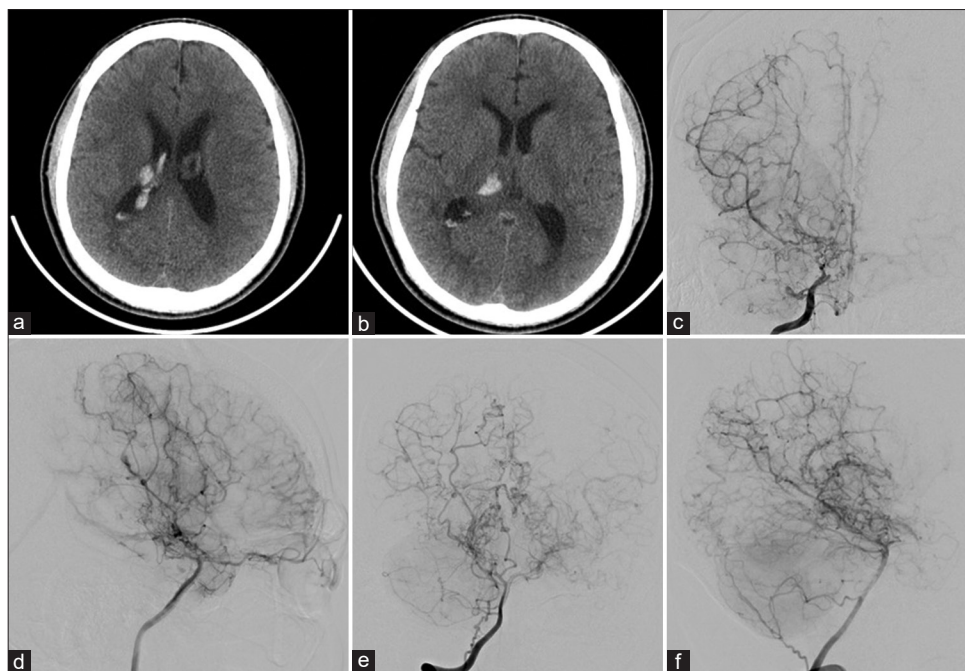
(a and b) Computed tomography revealing thalamic hemorrhage. (c) Anterior-posterior and (d) lateral angiography of the right internal carotid artery before bypass surgery showing Suzuki grade 4 moyamoya disease. (e) Anterior-posterior and (f) lateral angiography of the right vertebral artery demonstrating development of the thalamic channel.
